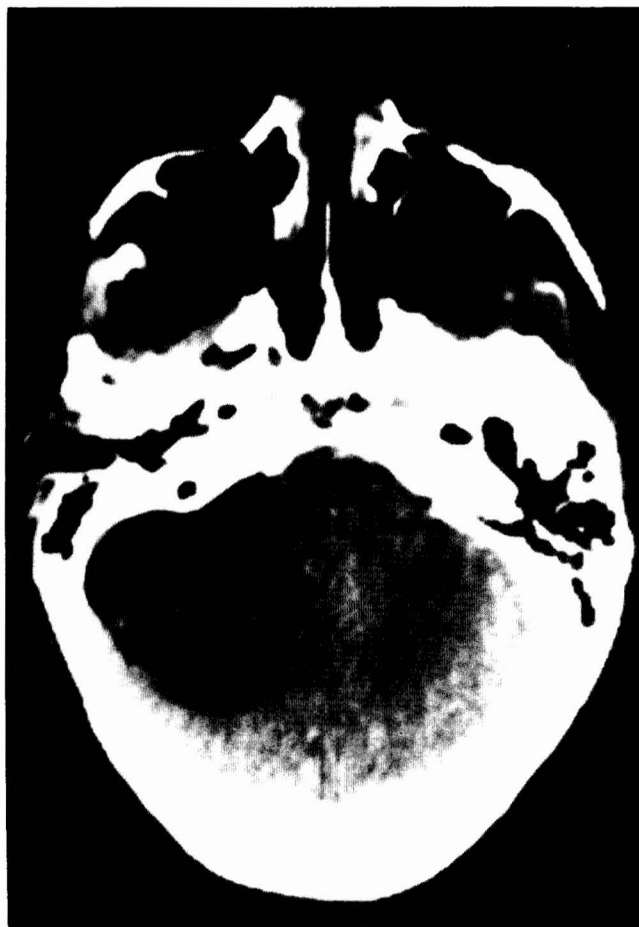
Case 3. Contrast-enhanced cranial CT scan showing well-demarcated tumor in the right cerebellopontine angle. Note the heterogeneity due to areas of fat density within the meningioma.
